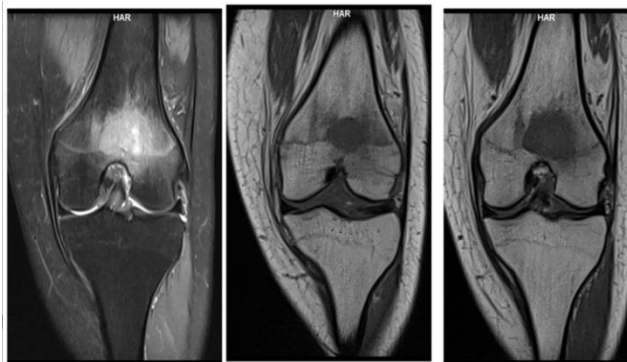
MRI Knee revealing a lytic lesion in the left patella and distal femur, pre-surgery
